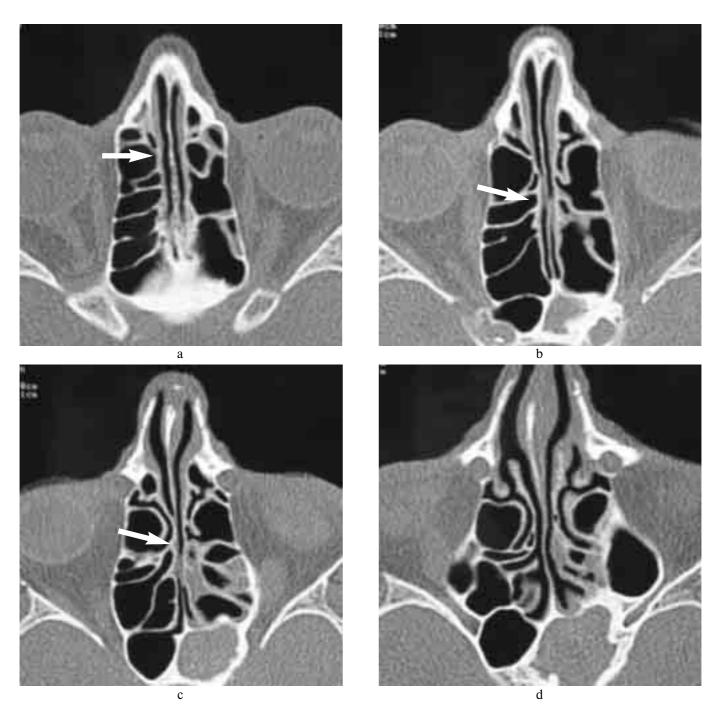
Axial CT-scans at the level of the olfactory clefts shows that the nasal fossae are laterally limited by a continous bony wall named conchal lamina (arrow) (a = superior, d = inferior).
